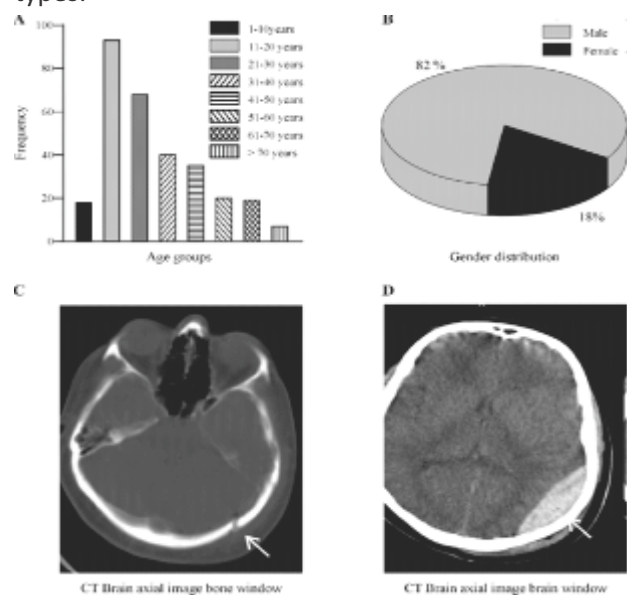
Age (A) and Gender (B) Wise Distribution of The Patients. CT-Brain Axial Image Bone Window (C) And Brain Window (D) Showing Linear Fracture of Left Parietal Bone and Associated Extradural Hematoma.
